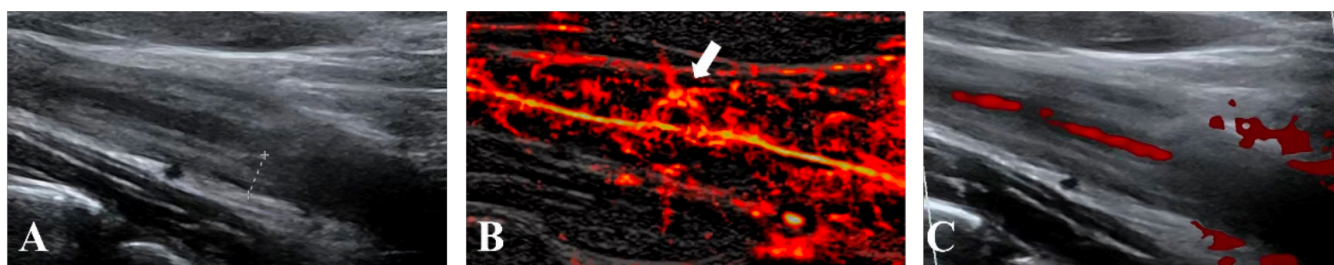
Representative imaging of patients with active Takayasu's arteritis, with carotid vasa vasorum detected on super-resolution ultrasound (SRUS) microvascular imaging. A: Initial B-mode US (December 2023) demonstrates carotid wall thickening (4.00 mm). B: Concurrent SRUS microvascular imaging reveals vasa vasorum within the thickened artery wall (white arrow), correlating with active disease (NIH score: 3). C: Follow-up B-mode US imaging (Jun 2024) after 6.2 months of therapy shows persistent wall thickening (4.20 mm) with unabated inflammatory activity (NIH score: 3). NIH: National Institute of Health.
